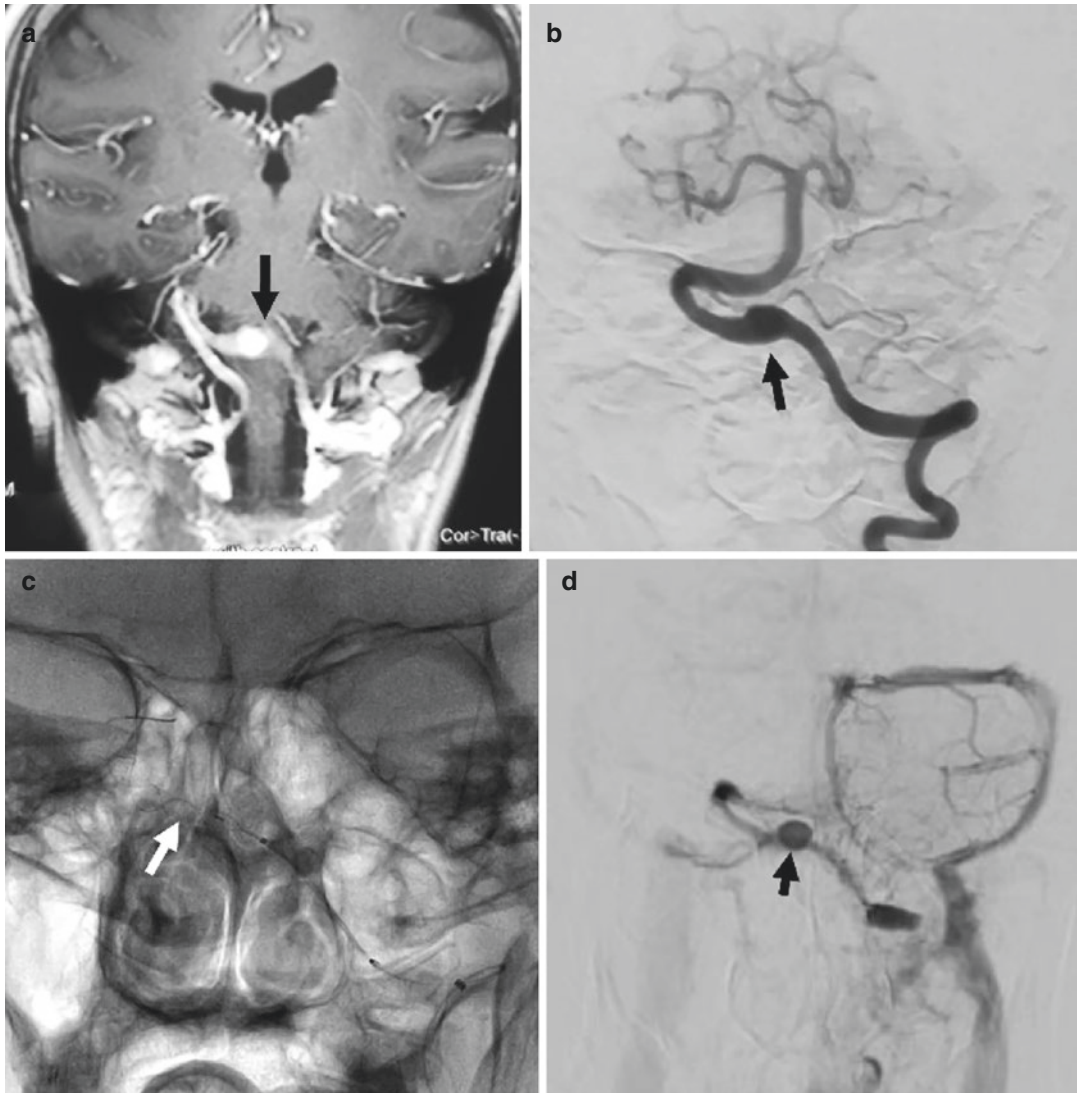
A 58-year-old woman presented with an incidental vertebral artery aneurysm. (a) Coronal view of the enhanced MR image showing a fusiform aneurysm of the left vertebral artery (arrow). (b) Frontal view of the left vertebral artery injection showing a fusiform aneurysm (arrow). (c) Frontal view of unsubtracted image showing
